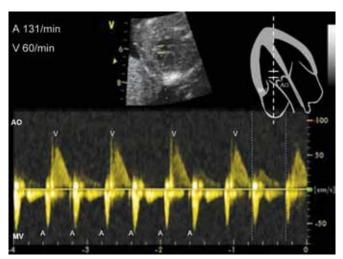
Two to one atrioventricular block is shown by simultaneous aortic and mitral Doppler interrogation
